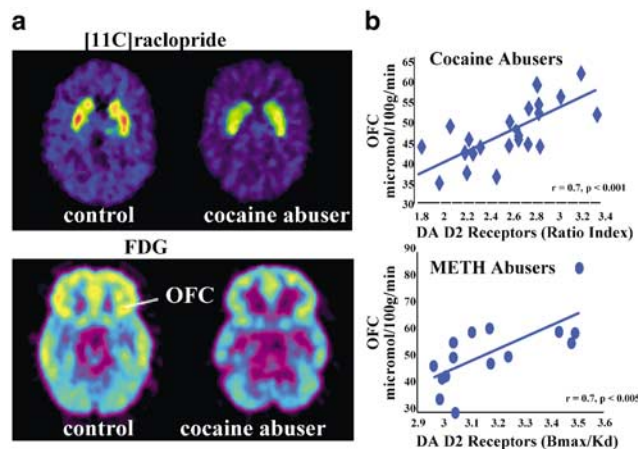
(a) Images obtained with [¹¹C]raclopride (to measure DA D2 receptor availability) and with FDG (to measure brain metabolism) in a control and in a cocaine abuser. Note the reduction in DA D2 receptors in basal ganglia and the reduced metabolism in the orbitofrontal cortex (OFC) in the cocaine abuser when compared with the control. (b) Relationship between DA D2 receptor availability in striatum and regional brain metabolism in OFC in cocaine and in metamphetamine abusers.
